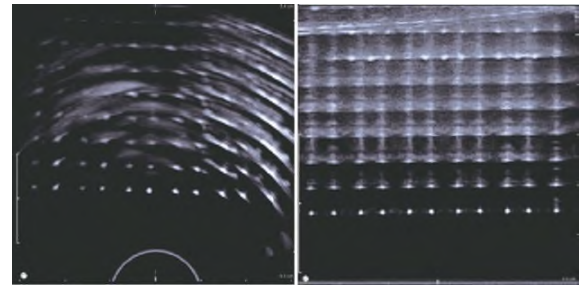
Ultrasonic calibration grid point image
